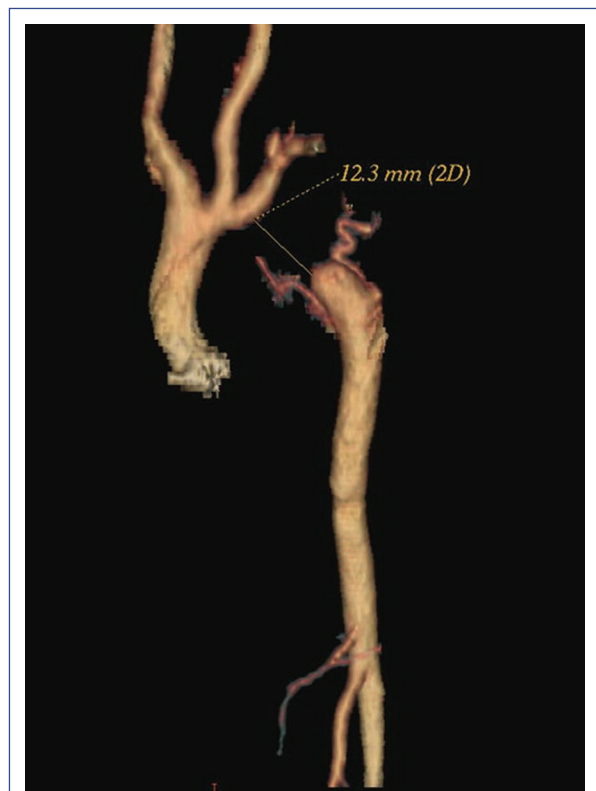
CT angiography. Aortic arch with supra-aortic vessels, discontinuity with the descending aorta, and small intercostal arterial vessels in the upper segment of the descending aorta are observed.
